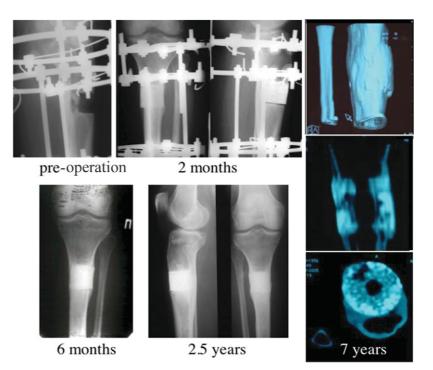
Repair of non-union bone defects using hydroxyapatite scaffolds associated with bone marrow stromal cells. As seen on the pre-operative radiograph a 4 cm gap is observed in the proximal tibia. Following implantation of the scaffold/cell structure bone callus formation is evident; this further progressed at 6 months with bone-implant integration evident. Complete bone-implant integration was observed at 2.5 years post-operation. CT scans at 7 years showed the complete healing of the non-union with the presence of a medullary channel and new bone within the HA scaffold pores (HA scaffold still present 7 years post-operation). Figure kindly provided by Dr E. Kon, Istituti Ortopedici Rizzoli, Bologna, Italy. This figure was published in Tissue Engineering, Volume 13, 2007⁴⁸ by Mary Ann Liebert, Inc., Publishers.
